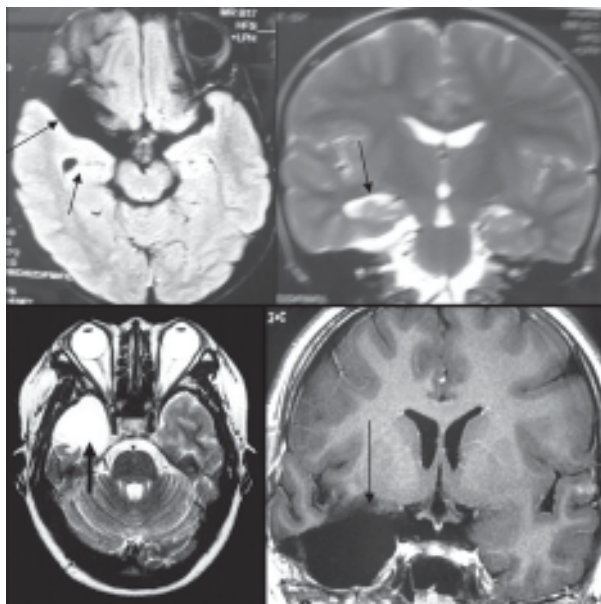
A-MRI of brain (FLAIR) coronal image and B-Axial mage showing right mesial temporal sclerosis (MTS) with compensatory dilatation of temporal horn in comparison to left temporal horn. C&D-MRI of brain T1 weighted images coronal and axial view respectively after amygdalohippocampectomy and standard anterior temporal lobectomy.
